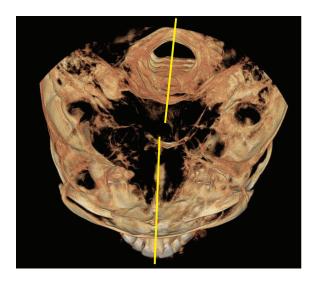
Spine-cranium asymmetry in NM patients. CBCT reconstruction of an axial view, demonstrates a significant asymmetry in the patient's spinal and cranial axes.
